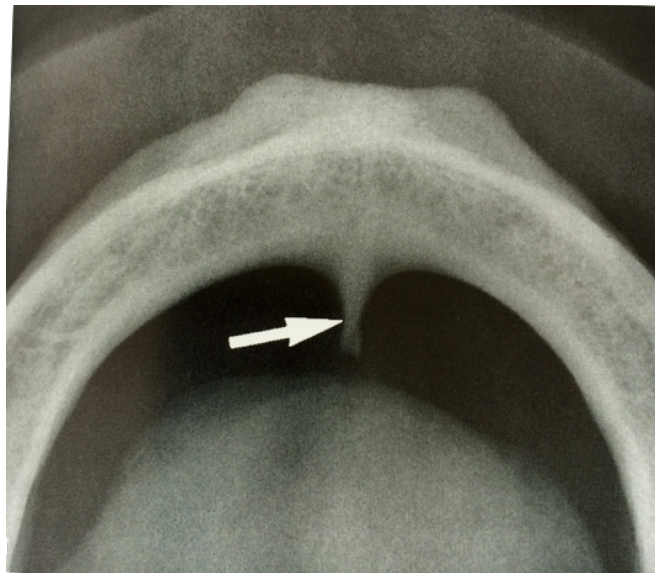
Aspecto radiográfico dos TG observados em radiografia periapical da região anterior da mandíbula.
